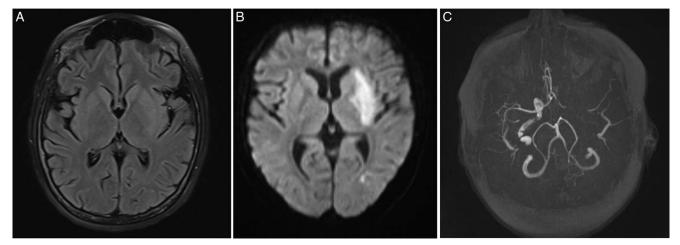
MRI, before thrombectomy at 6 h of onset of patient's symptoms. (A) Mild hyperintensity in the left insula cortex in the FLAIR sequence. (B) Mild hyperintensity in left basal ganglia in the DWI sequence. (C) Occlusion in M1 segment of left MCA in 3D-TOF sequence. FLAIR, fluid-attenuated inversion recovery; 3D-TOF, 3D time of flight; DWI, diffusion weighted imaging; MCA, middle cerebral artery.
